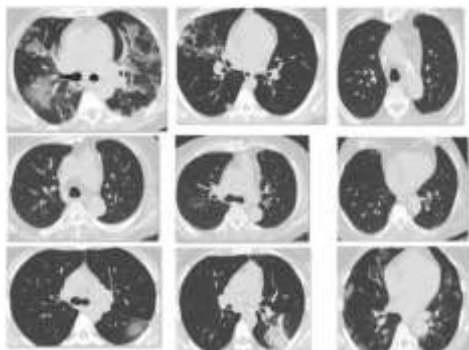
CT scan images of SARS-CoV-2 infection +ve samples in axial projection
